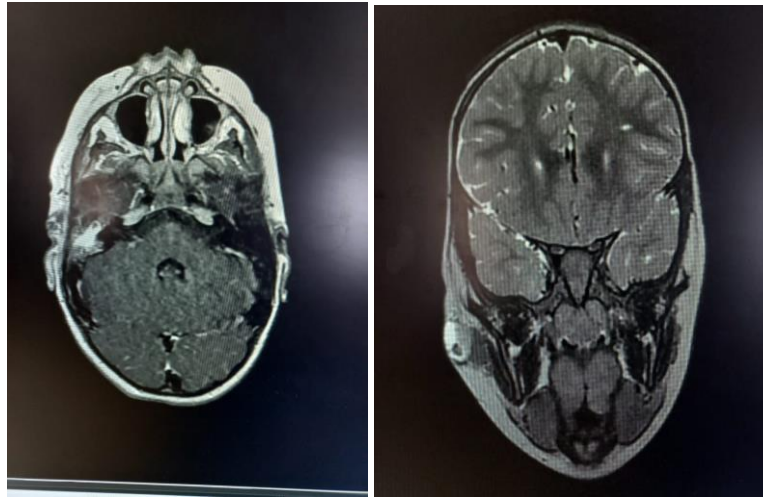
MRI of the temporal bone and neck (T1 post-gadolinium). Left: axial view showing opacification of the right middle ear and external auditory canal with restricted enhancement and individualization of a retroauricular fistulous tract. Right: coronal view demonstrating right intraparotid necrotic lymphadenopathy (15 × 13 mm) with parotid gland enhancement and skin fistulization
